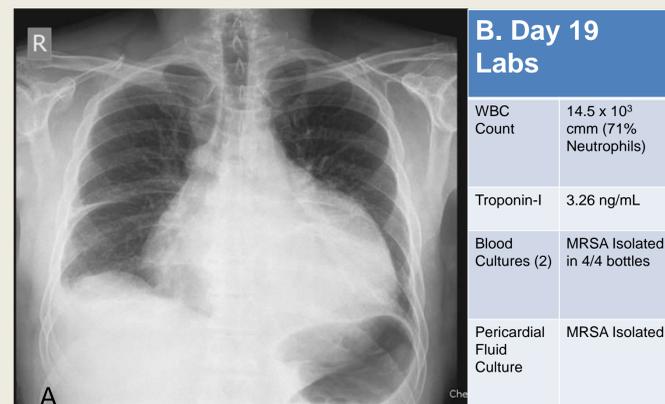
(A) Chest x-ray on Day 19 showing enlarged cardiac silhouette and right pleural effusion. (B) Notable laboratory results.
